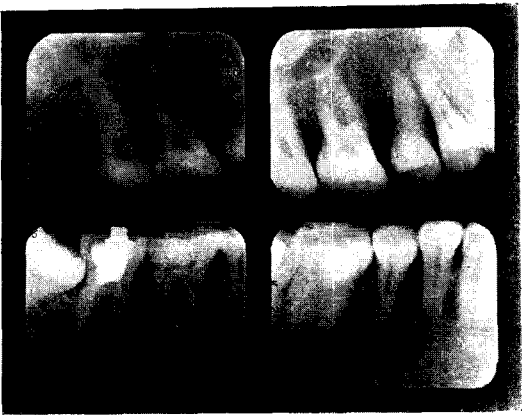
Periapical radiographs demonstrating regeneration of alveolar lamina dura and trabeculae.
